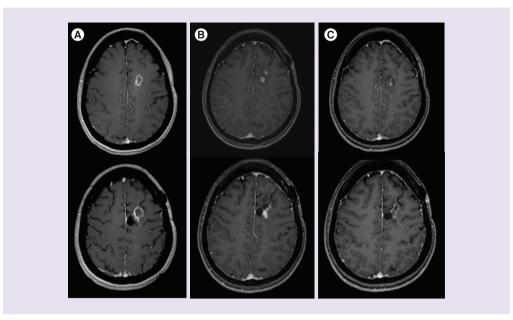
MRI imaging, axial postgadolinium T1-weighted imaging. Baseline brain MRI images (A) before starting ivosidenib demonstrated post-LITT changes in the inferior aspect of the surgical cavity in the high left frontal lobe. Brain MRI images at 6 months (B) and at 50 months (C) postinitiation of ivosidenib demonstrated evolving post-LITT changes with no evidence of tumor recurrence. LITT: Laser interstitial thermal therapy.
